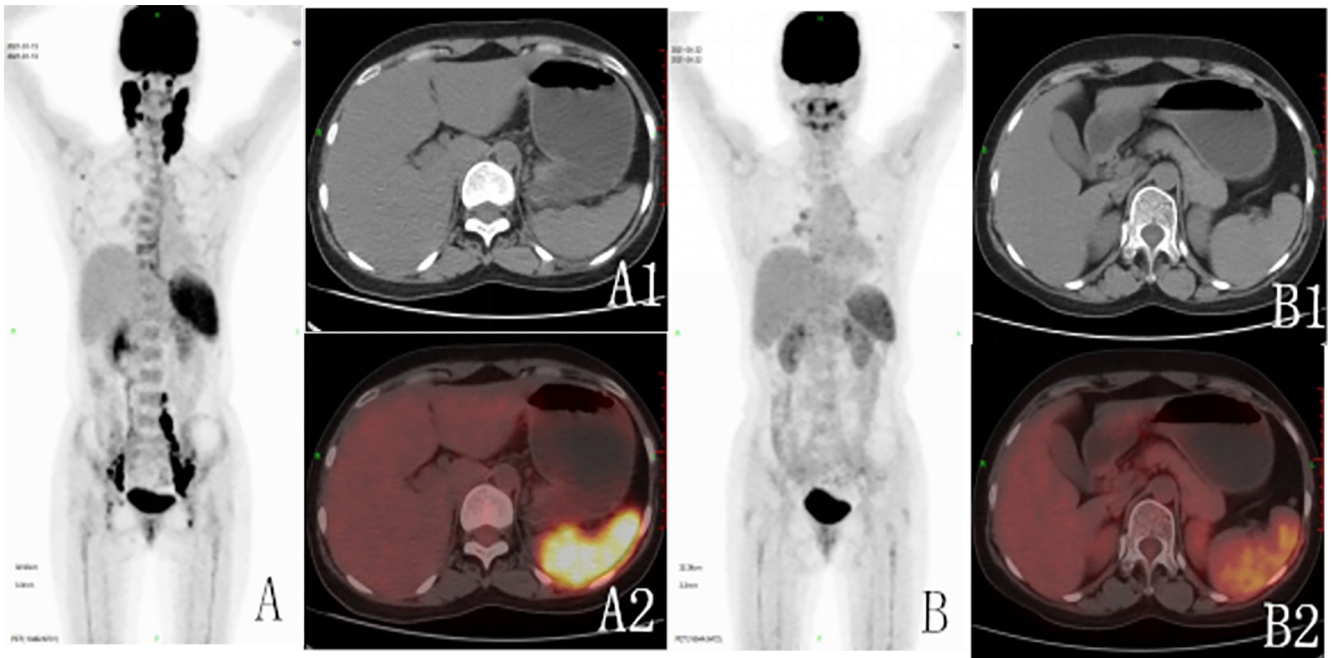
^{18}F -FDG PET/CT imaging of a 35-year-old patient with lymphatic system involvement of LCH before and after treatment. (A-A2) Before treatment multiple swelling lymphadenopathy and spleen show hypermetabolism; (B-B2) cervical and basin swelling lymph nodes disappear, the metabolic activity of spleen decrease. (A,B: PET MIPs; A1,B1: Axial CTs; A2,B2: PET/CT fusion images).
